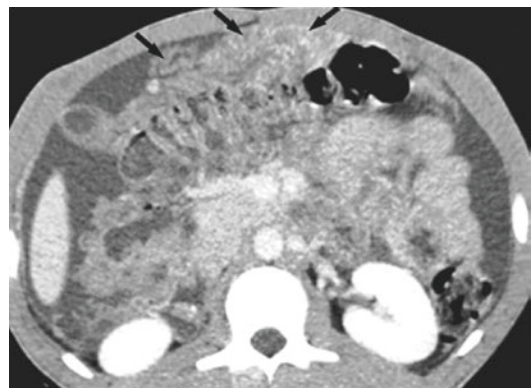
Diagnosis of PM on computed tomography. View of an omental involvement such as enhancing nodules or omental cake
